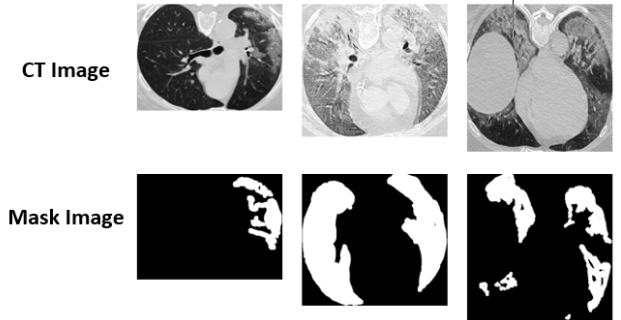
Example CT Images and Their Masks
